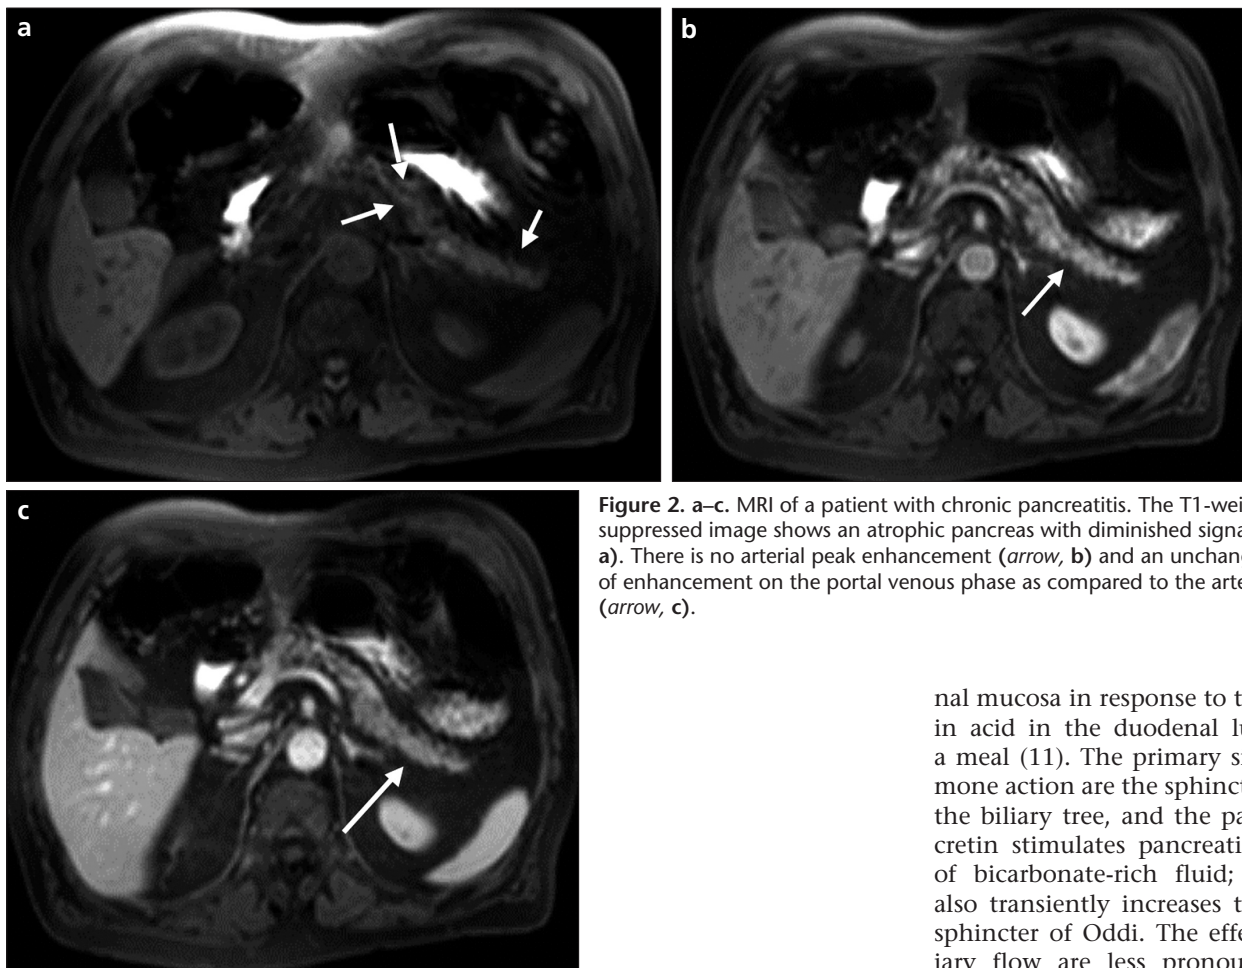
a–c. MRI of a patient with chronic pancreatitis. The T1-weighted fat-suppressed image shows an atrophic pancreas with diminished signal (arrows, a). There is no arterial peak enhancement (arrow, b) and an unchanged level of enhancement on the portal venous phase as compared to the arterial phase (arrow, c).
